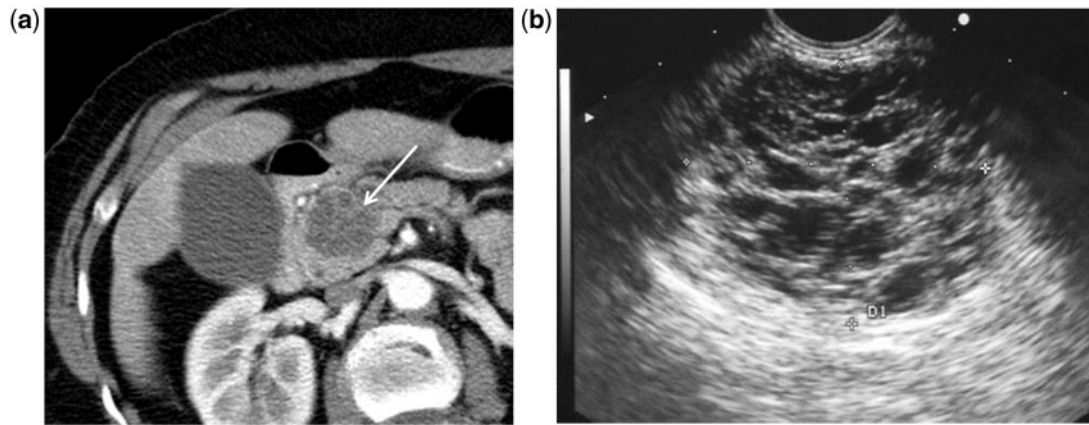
Cystic pancreatic incidentaloma in a 71-year-old woman who presented with pain in the left lower quadrant. (a) MDCT shows a sponge-like, multiseptated cystic mass in the pancreatic head without biliary or pancreatic ductal obstruction. Despite this classic CT appearance of a serous cystadenoma, the patient and her physician were concerned and endoscopy ultrasonography (b) was performed. This study confirms the innumerable microcystic structures comprising this tumor.
